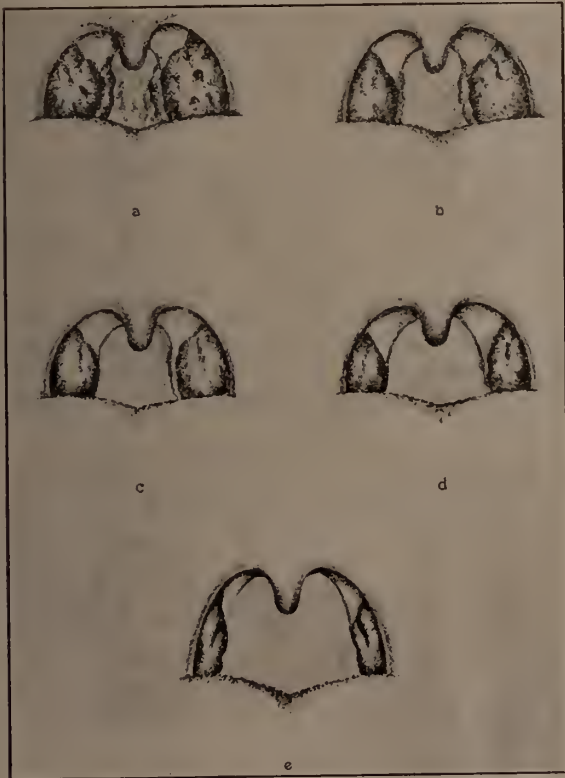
a. Tonsils before X-ray treatment; large, ragged; crypts contain pus; large mass of lymphoid tissue behind posterior pillars. b. Two weeks after treatment; tonsils reduced; surface smooth and clean; mass behind pillars reduced. c. Four weeks after treatment; tonsils markedly reduced; pale and smooth; no exudate on deep pressure. d. Eight weeks after treatment; small amount of exudate. e. Six months after treatment; tonsils small, normal in appearance; no exudate on deep pressure. Lymphoid tissue behind pillars practically gone. Hemolytic streptococci disappeared from throat by second week after treatment.
